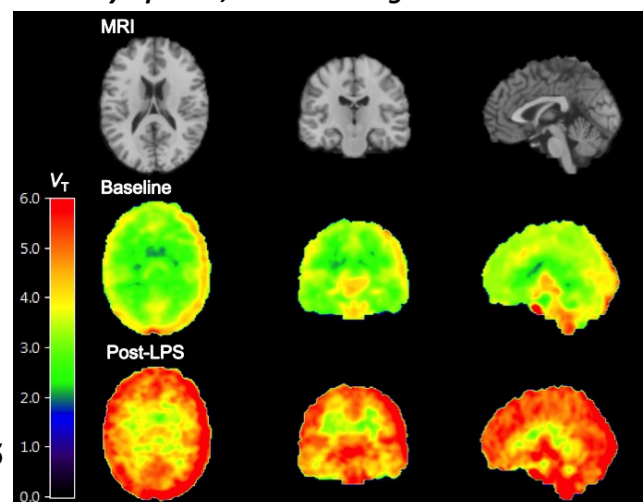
LPS administration significantly increases [^{11}C]PBR28 binding (V_T) from baseline (average parametric images from $n=8$). Magnetic resonance image (MRI) is shown for anatomical reference (top row).
